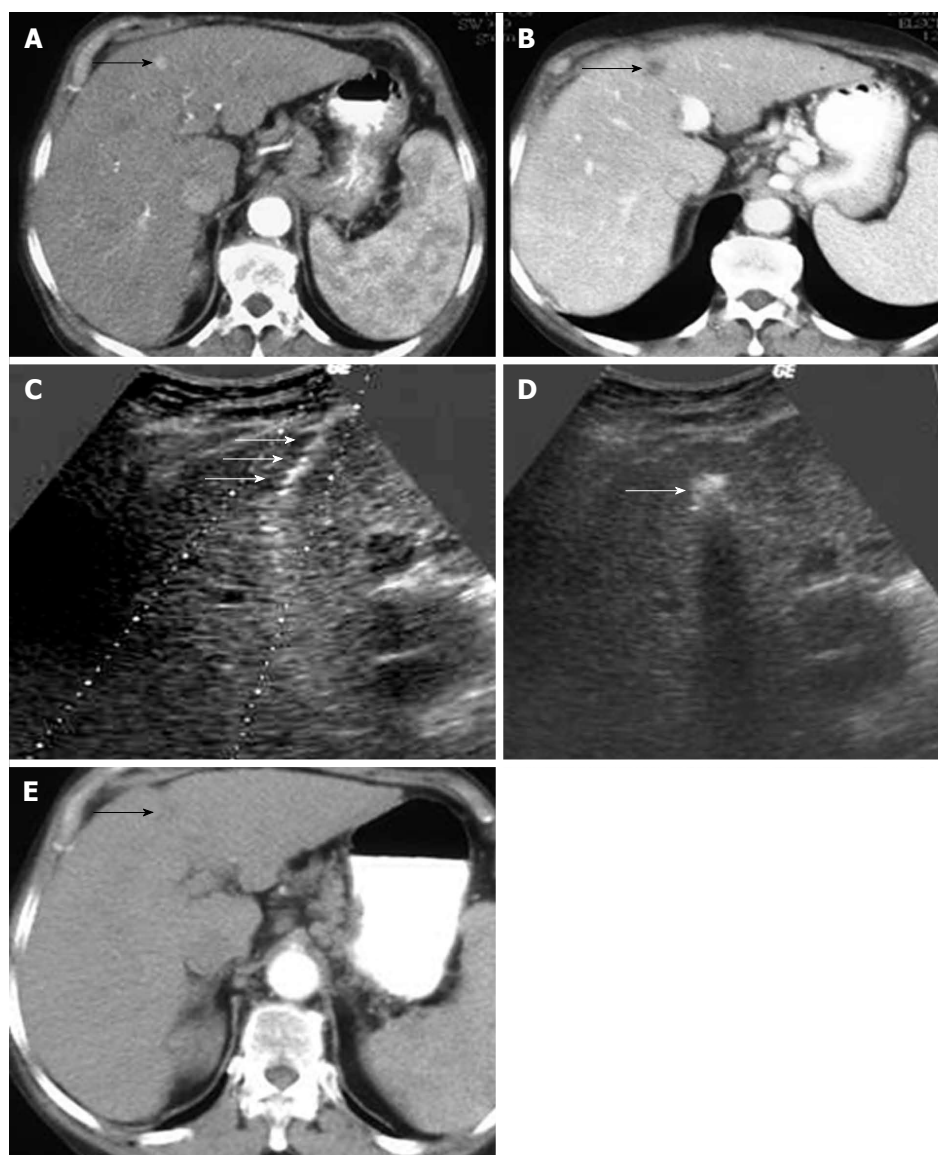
Ethanol injection treatment for hepatocellular carcinoma. A: Very early hepatocellular carcinoma pre-percutaneous ethanol injection treatment (Arterial phase); B: Very early hepatocellular carcinoma pre-percutaneous ethanol injection treatment (Portal phase); C: Percutaneous ethanol injection procedure (Ultrasound guidance fine needle puncture); D: Percutaneous ethanol injection procedure (Ethanol aggregation after ultrasound guidance percutaneous ethanol injection); E: Computed tomography control arterial phase after 1 year (Sustained complete response).
